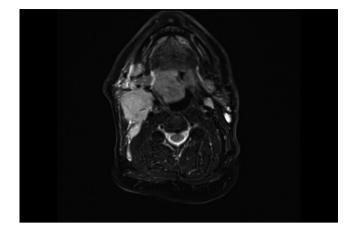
MRI of 5.3 cm right tonsillar malignancy centered on the right palatine tonsil. This extends inferiorly to abut and displaces the epiglottis with effacement of the right vallecula. There is lateral involvement of the constrictor muscles and extension across the midline
